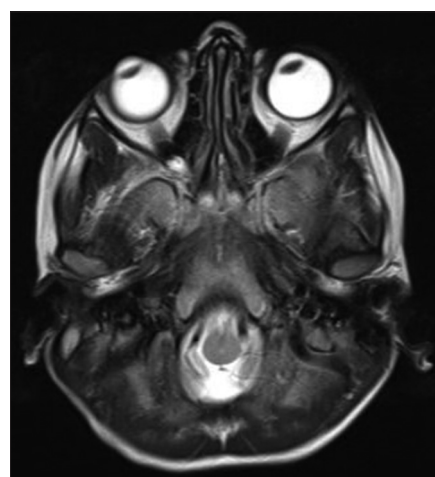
T2-weighted image at the level of the orbits shows normal signal within the optic nerves bilaterally
